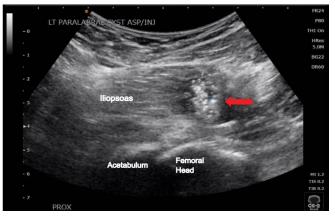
Ultrasound of anterior paralabral cyst status-post cyst rupture (red arrow).
